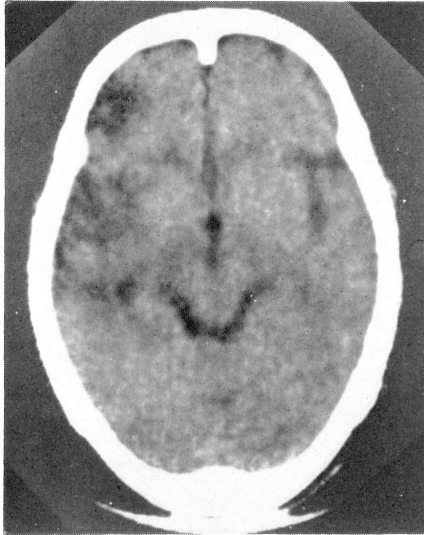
CT scan, 18 days after the injury, showed disappearance of mottled like-change in the frontal region.
